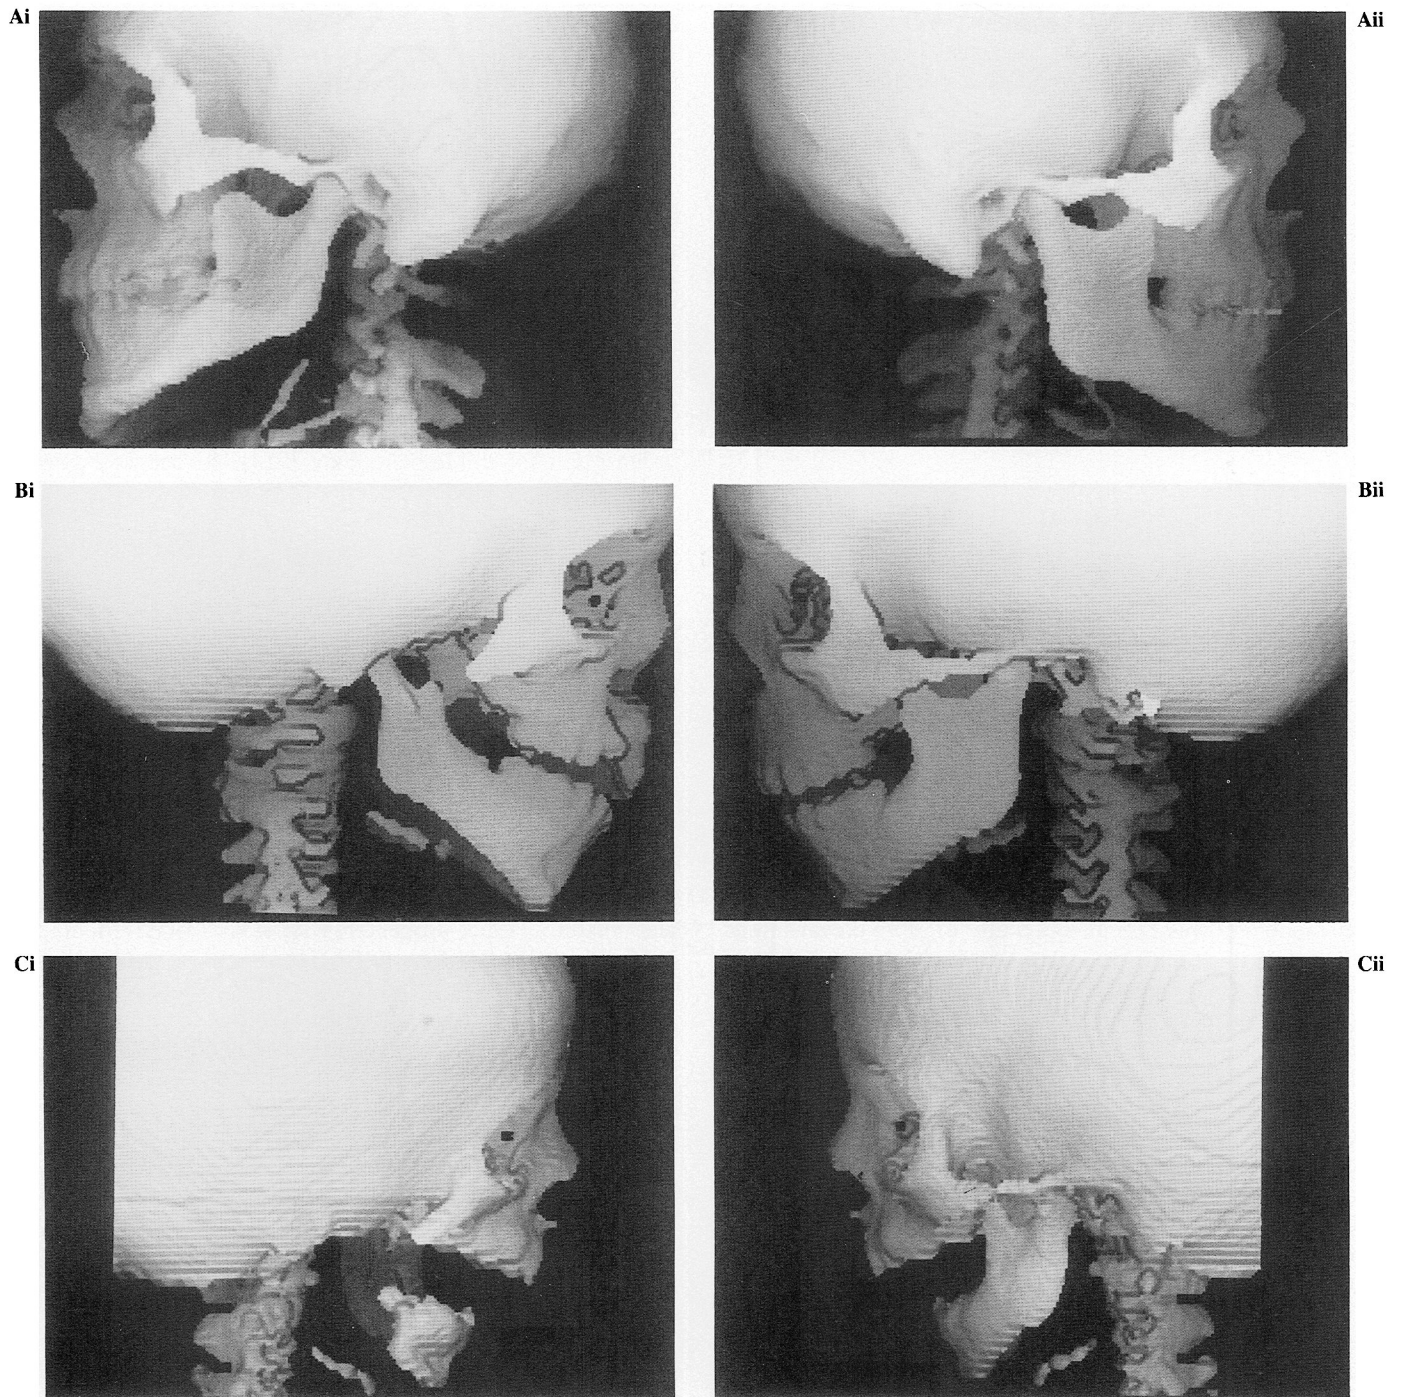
Examples of Pruzansky (1969) classification of mandibular dysmorphology. Images are lateral surface shaded osseous reconstructions from CT scan, method Vannier-Marsh (Marsh and Vannier, 1988; Vannier et al, 1988). A, 17-year-old male with left unilateral hemifacial microsomia having Pruzansky grade I mandibular dysmorphology. (i), Clinically affected side. The salient features of Pruzansky grade I are the relatively normal shape and reduced size of the affected hemimandible. Comparison with the unaffected side demonstrates hypoplasia of the body of the zygoma, elevation of the zygomatic arch, broadening of the mandibular coronoid process, reduction in the height of the mandibular ramus, and hypoplasia and lateral deviation of the inferior body of the mandible. The stylohyoid ligament is partially calcified on the affected side. (ii), Clinically unaffected side. B, 4-year-old female with right unilateral hemifacial microsomia having Pruzansky grade II mandibular dysmorphology. Same patient as Figure 1B. (i), Clinically affected side. The salient features for Pruzansky grade II are the mildly dysmorphic shape and reduced size of the affected hemimandible. Comparison with the unaffected side demonstrates hypoplasia of the body of the zygoma, hypoplasia of the temporal process of the zygoma, aplasia of the zygomatic process of the temporal bone, hypoplasia of the mandibular coronoid process, reduction in height and width of the mandibular ramus, hypoplasia and lateral deviation of the inferior body of the mandible. (ii), Clinically unaffected side. C, 3-month-old male with right unilateral hemifacial microsomia having Pruzansky grade III mandibular dysmorphology. (i), Clinically affected side. The salient features for Pruzansky grade III are the markedly dysmorphic shape and reduced size of the affected hemimandible. Comparison with the unaffected side demonstrates hypoplasia of the body of the zygoma; dysmorphology of the temporal process of the zygoma; aplasia of the zygomatic process of the temporal bone; aplasia of the mandibular condyle, coronoid process and ramus; hypoplasia of the mandibular body; and absence of the external auditory meatus. (ii), Clinically unaffected side.
